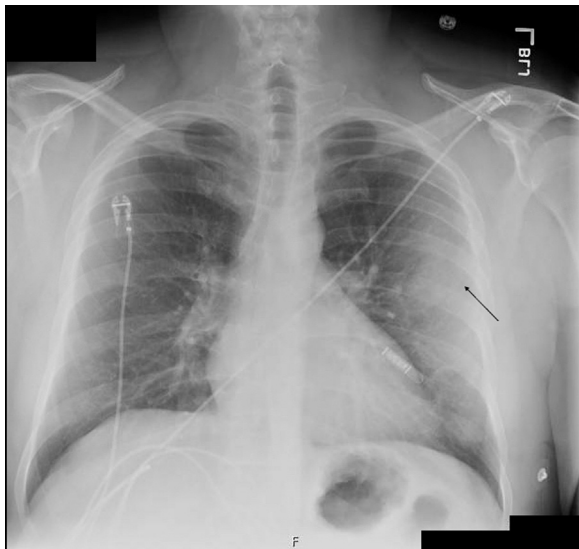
Postoperative day 1 chest radiograph, posterior-anterior view. Arrow indicates patchy airspace density in left lung periphery.
